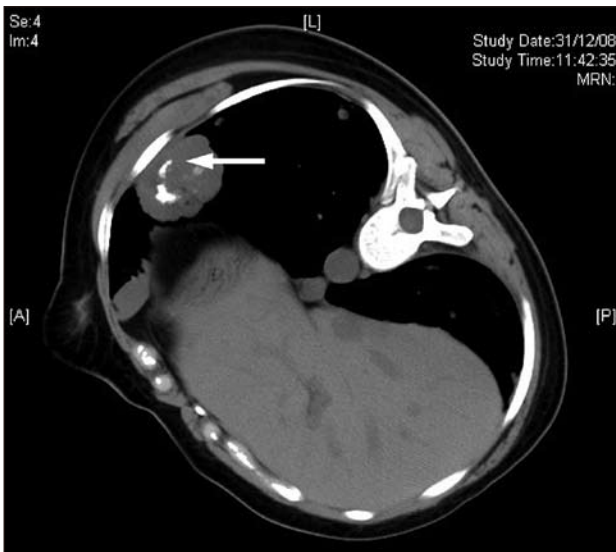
Computed tomography image taken during fine needle aspiration biopsy in 2008. Coarse calcification (arrow) is clearly demonstrated on the largest lung lesion, which showed no significant interval increase in size.
